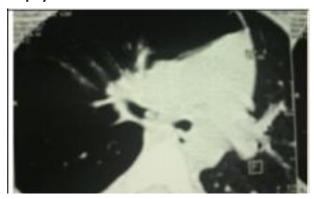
CT scan showing foreign body in right main stem bronchus and right lung emphysema
